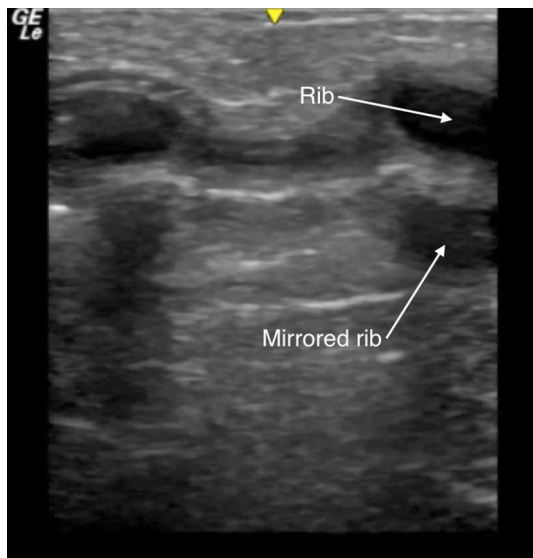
Pneumothorax in an infant; figure-of-eight sign shown in ribs transparent to ultrasound mirrored across the pleural line
